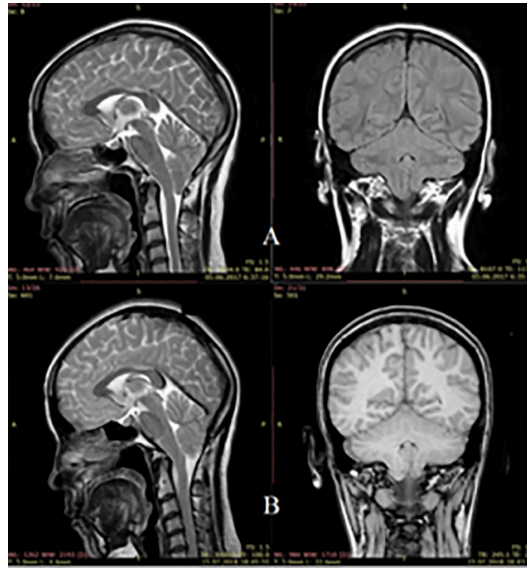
Brain MRI (T1-2 mode in the sagittal and frontal planes) of a patient with isolated Arnold-Chiari malformation type I before and after CCD with revision of the posterior cranial fossa and duroplasty.
